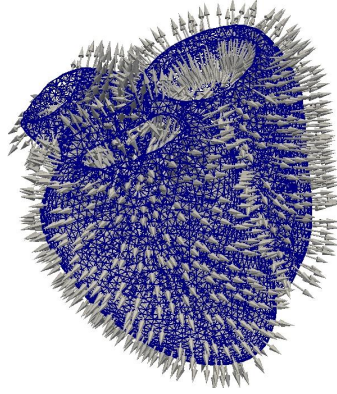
A triangulated mesh computed from a segmentation of the myocardium of a MRI image (blue). At each face (triangle) of the surface is associated a Direct delta currents whose vector is the normal at the surface and the norm is the area of the surface.
